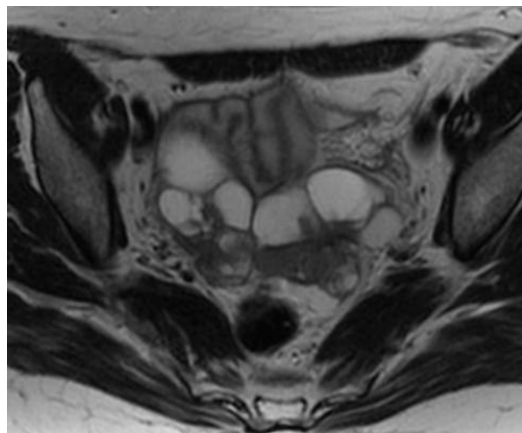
Bilateral cystic adenocarcinoma showing morphologic features indicative of a malignant adnexal mass. Solid cystic mass, with irregular and thickened septations. Axial T2-weighted image.
